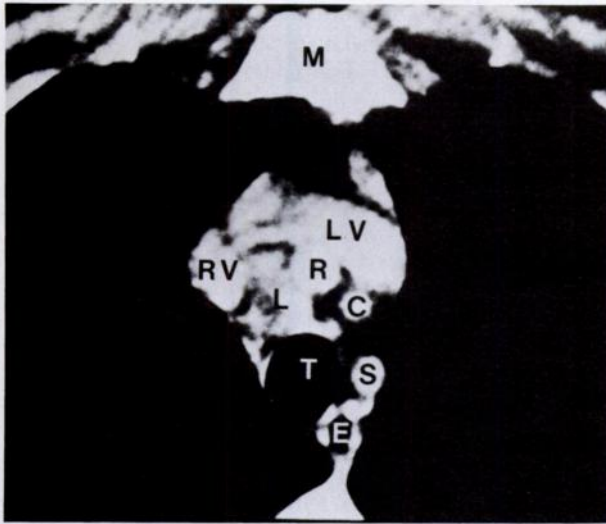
Chest CT scan, case 2, before MV replacement. M=manubrium; LV=left brachiocephalic vein; RV=right brachiocephalic vein; L=lymph node; R=right brachiocephalic artery; C=left carotid artery; S=left subclavian artery; E=esophagus; T=trachea.
